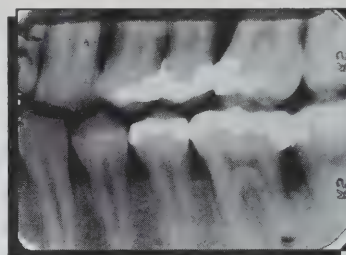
Patient's radiographs taken at 22 years of age. Note bone loss localized to premolar/molar regions.
